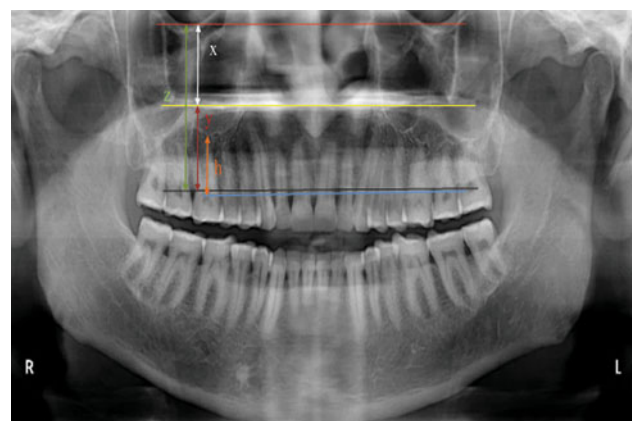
Distances measured on radiographic images of maxillae: (x) from line joining most inferior points of borders of bony orbits to line joining inferior margins of images of zygomatic processes; (y) from zygomatic process line (described above) to alveolar crest in between maxillary first and second molar regions; (z) from the interorbital line to the alveolar crest; (h) from the intercrestal line to the inferior margin of sinus floor as h
